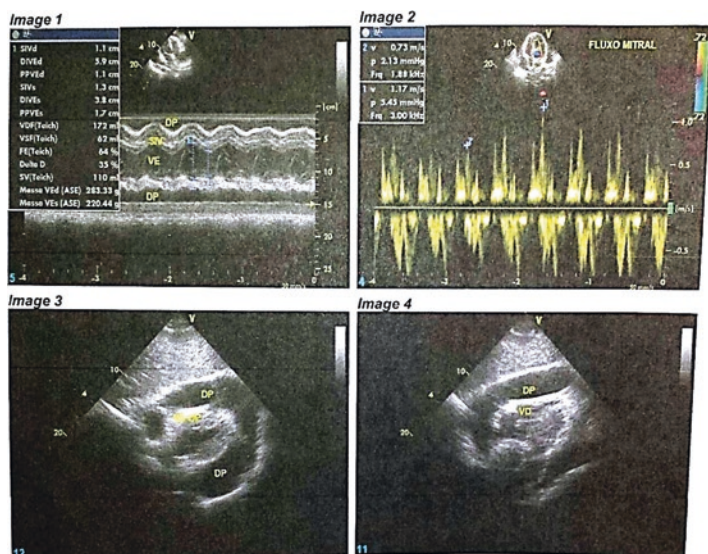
Doppler echocardiography showing pericardial effusion (DP) important
